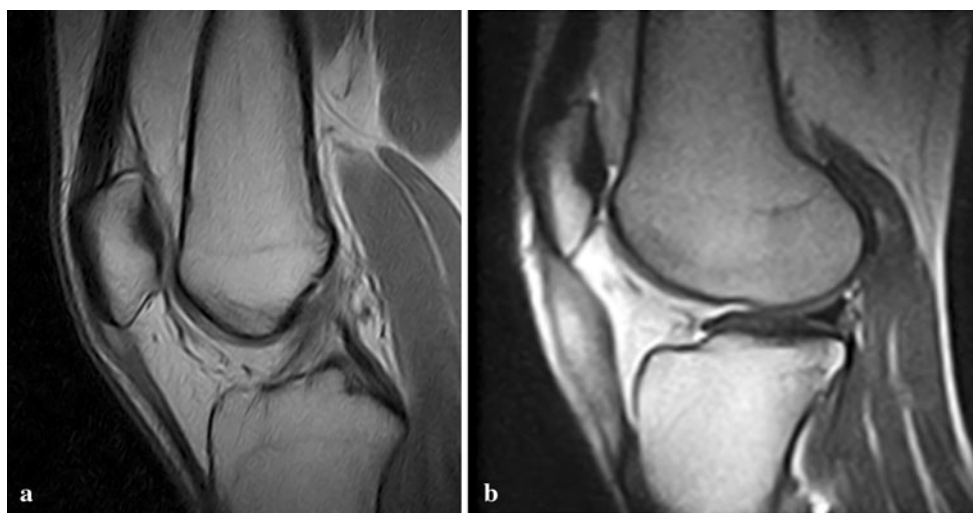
a Case 2 MRI of the left knee demonstrating evidence of patellar tendinitis. b Repeat MRI 2 months following PRP injection demonstrating marked thickening of the patellar tendon
